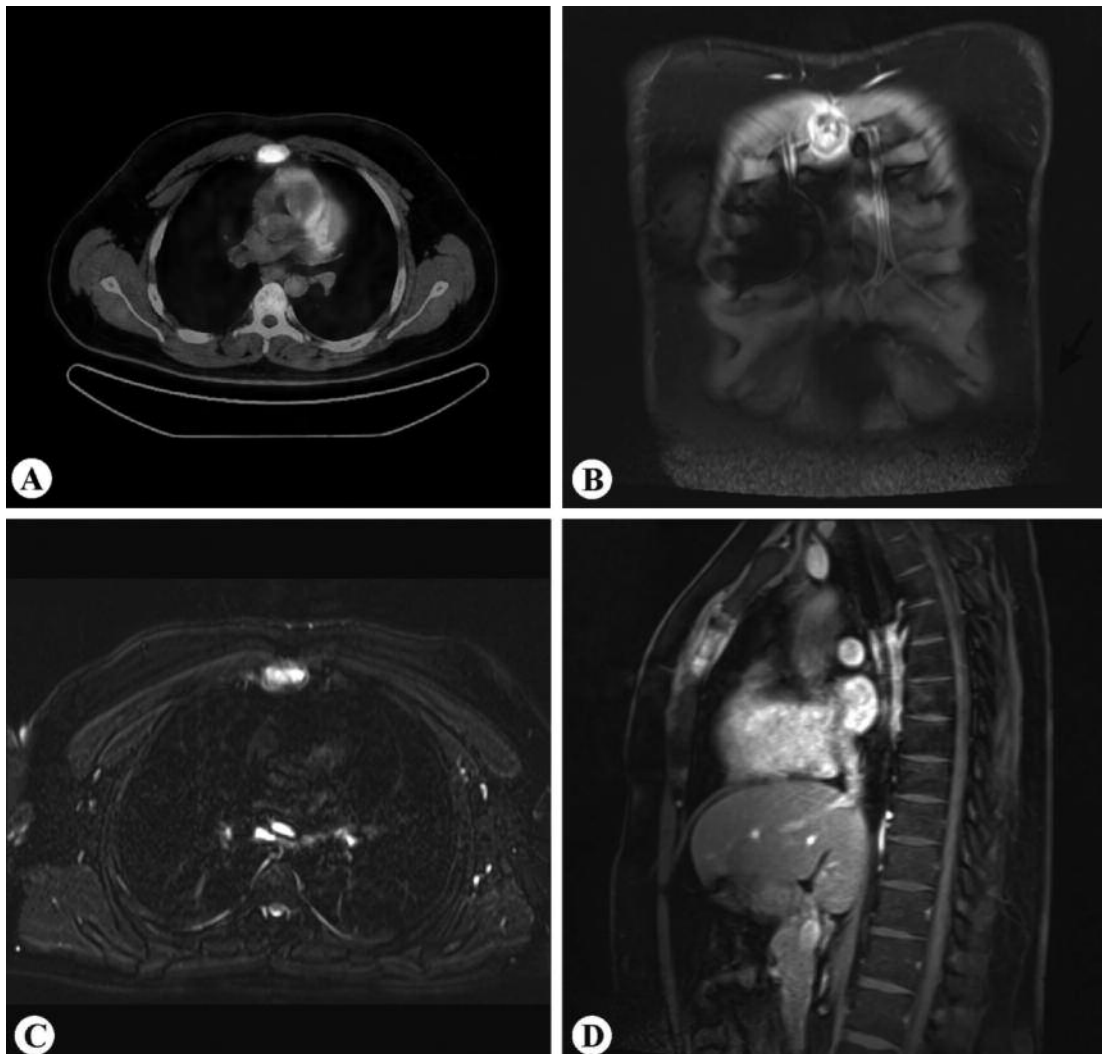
A, Axial PET CT shows focal increased FDG involvement in the corpus sterni. B, D, Coronal and sagittal post-gadolinium fat suppressed T1-weighted MR images reveal an expansile enhanced lytic mass lesion in the corpus sterni. C, On axial fat suppressed T2- weighted MR images, the lesion depicts high signal intensity.
